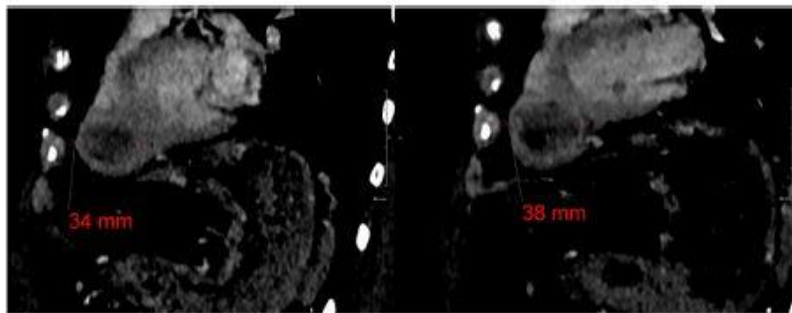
CT-scan with iodine contrast product injection performed at 3 months (right) and 6 months (left) after treatment, showing a progressive partial response.
